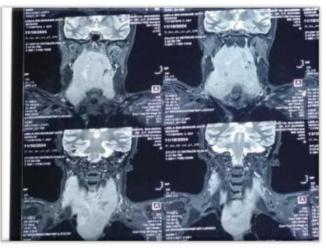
MRI Scan Showing Extension Of Lesion
